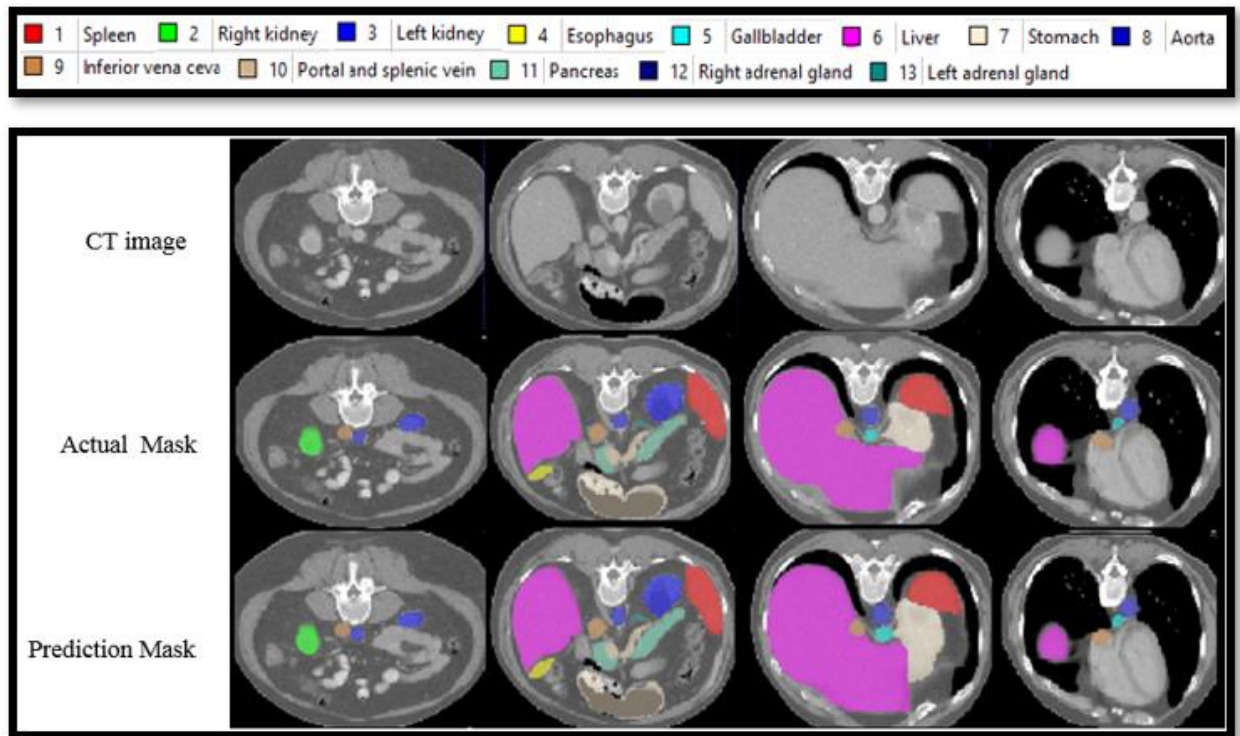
CT Image, actual mask and prediction mask
